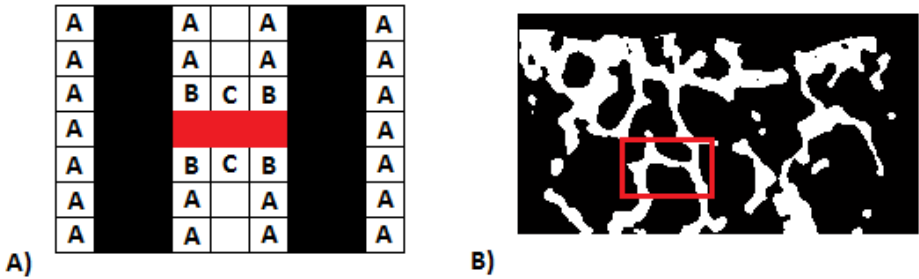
A) Representation of the creation of a bridge in red between fibers in black. $A:M3-A90$, $B:M5-A45$ and $C:M3-A0$. B) Example from a μ CT slice with a bridge shown in the red rectangle
